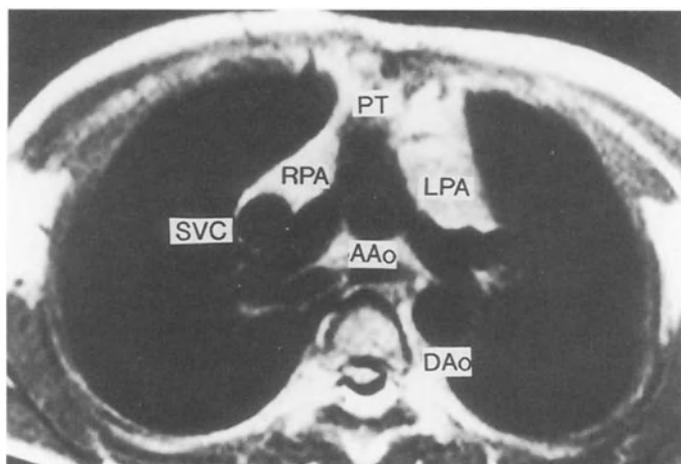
Transverse magnetic resonance imaging (MRI) view of the stenotic pulmonary trunk and bifurcation in a 3-year-old boy who had surgical repair for transposition of the great arteries, ventricular septal defect, and coarctation of the aorta at 1 month of age. The pulmonary trunk and the bifurcation are compressed by the ascending aorta. *AAo*, Ascending aorta; *DAo*, descending aorta; *LPA*, left pulmonary artery; *PT*, pulmonary trunk; *RPA*, right pulmonary artery; *SVC*, superior vena cava
